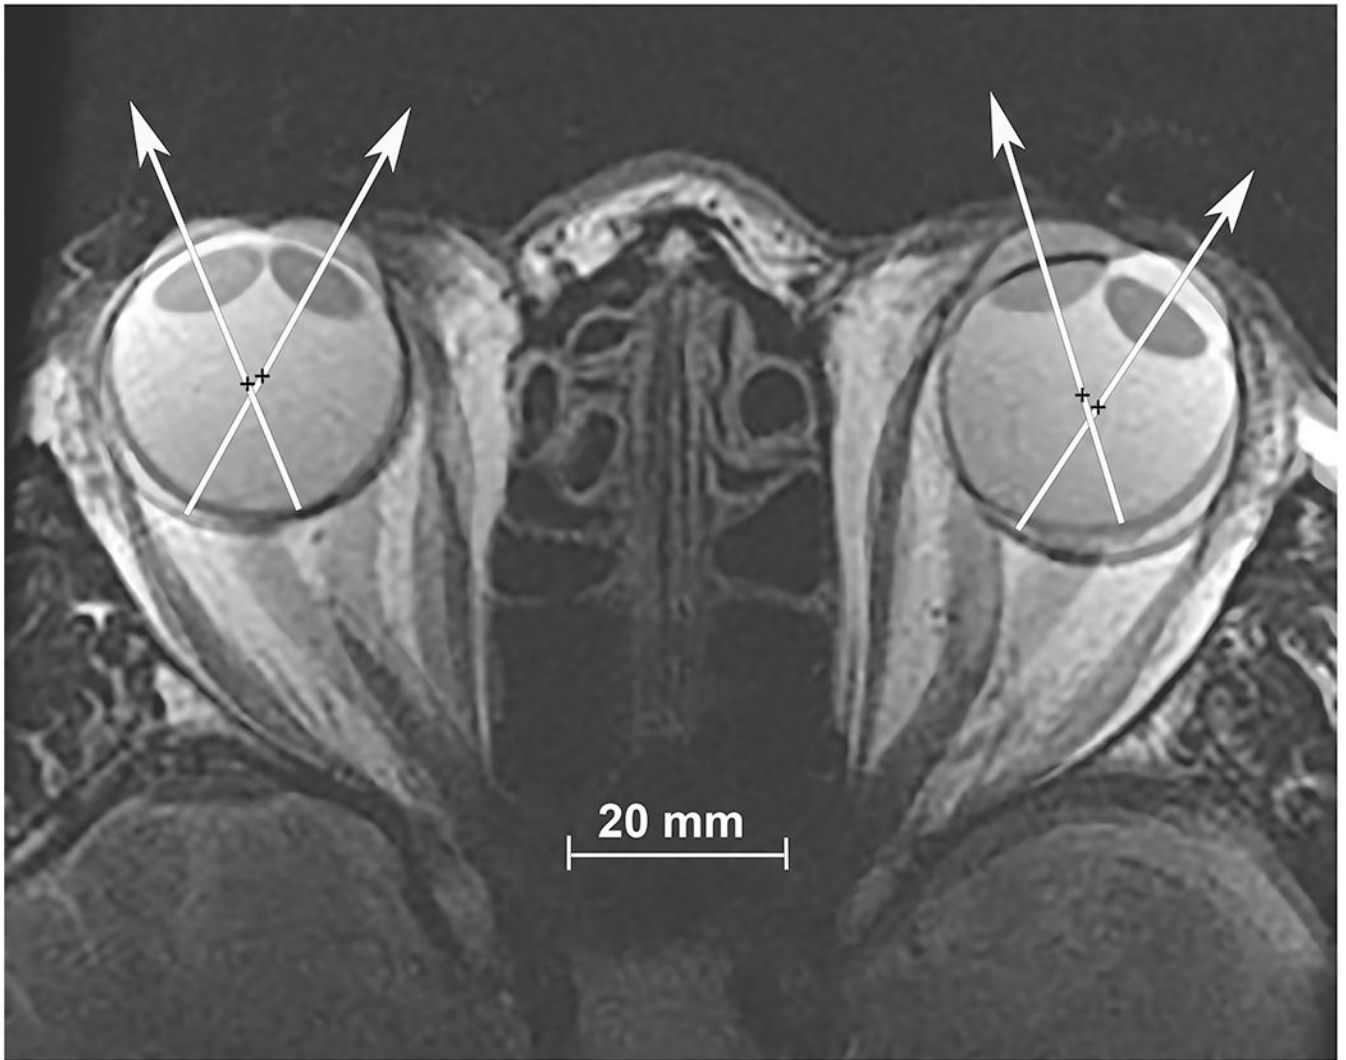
Axial, T2-weighted MRI obtained using surface coils in a normal subject fixating in right gaze, and superimposed at partial opacity on the image separately obtained in left gaze. Visual axes are depicted by superimposed white arrows, and rotational center by black crosses. Note the globe translation during this large horizontal rotation of each eye.
